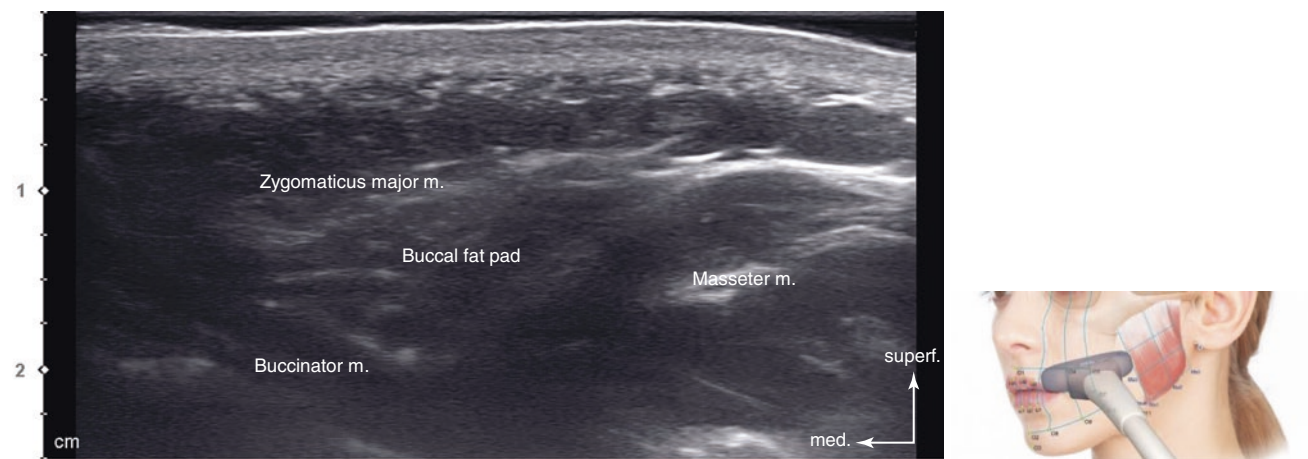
Ultrasonography of the intersection point of TL6 and PL3 (O5). B mode (transverse view, 15 MHz by linear transducer). (Published with kind permission of © Hee-Jin Kim 2020. All Rights Reserved)
